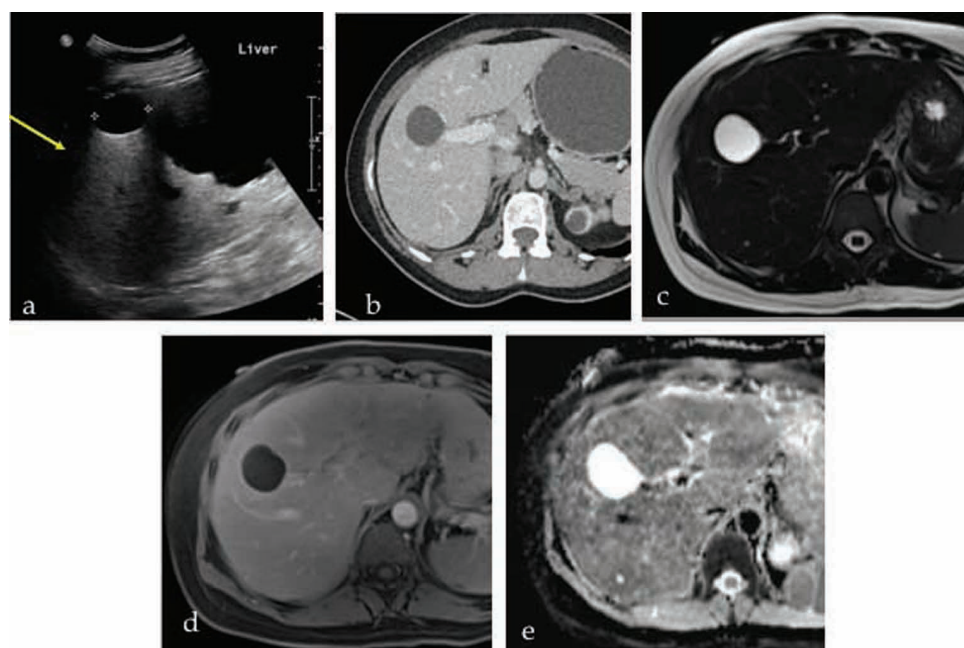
a. Ultrasound image of simple cysts shows well-defined anechoic lesions with posterior acoustic enhancement (arrow). b. Computed tomography image shows a hypodense lesion with imperceptible wall. c. Axial T2W image shows an intensely T2 bright well-defined lesion. d. Axial T1W post-contrast image shows no internal enhancement. e. Apparent diffusion coefficient map shows no restriction of diffusion.
